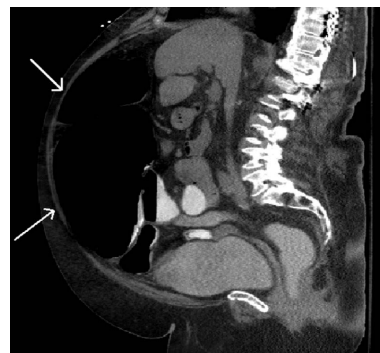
Abdominal CT scan sagittal view of colon distension (arrows) with cecum diameter of 12.5 cm.
